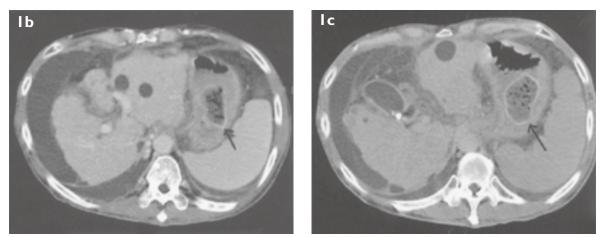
I Enhanced axial CT images of the upper abdomen taken during (a) arterial, (b) portal venous, and (c) delayed phases.
